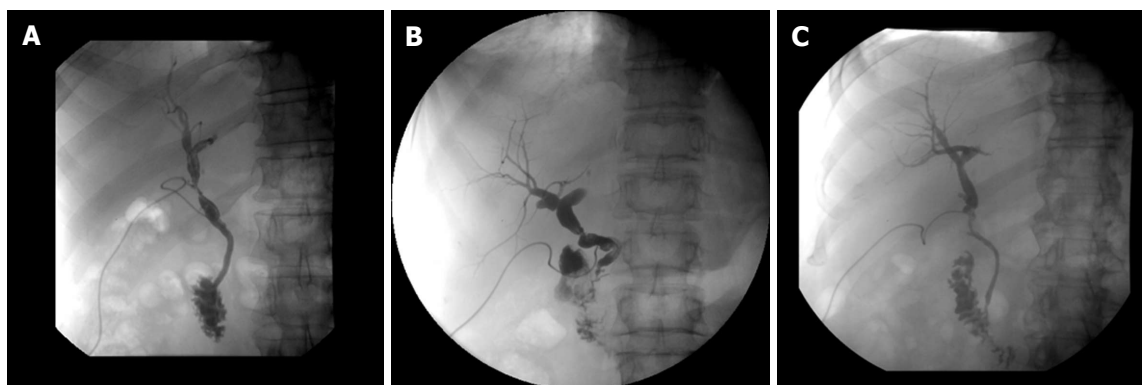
Different types of bile duct anastomotic pathologies: All T-tube X-rays six weeks after liver transplantation. A: Stenosis (> 30%) after side-to-side anastomosis, resolved after endoscopic stent treatment for 3 mo; B: Stenosis (> 30%) after end-to-end anastomosis, all lab values normal, no clinical relevance, no intervention; C: No anastomotic stenosis but incongruence of graft- and recipient bile duct, no clinical relevance, normal lab values, surveillance.
